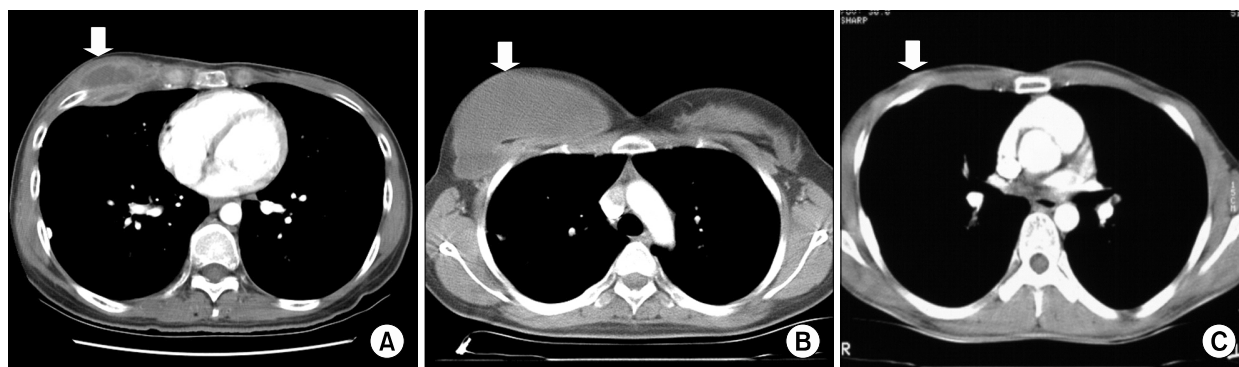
Chest CT scan showing a soft tissue mass (arrow) with a central low density and with peripheral rim enhancement in the inner and outer sides of the ribs (A), and only in the outer side (B). The subcutaneous fat layer (arrow) was only involved in one lesion (C).
